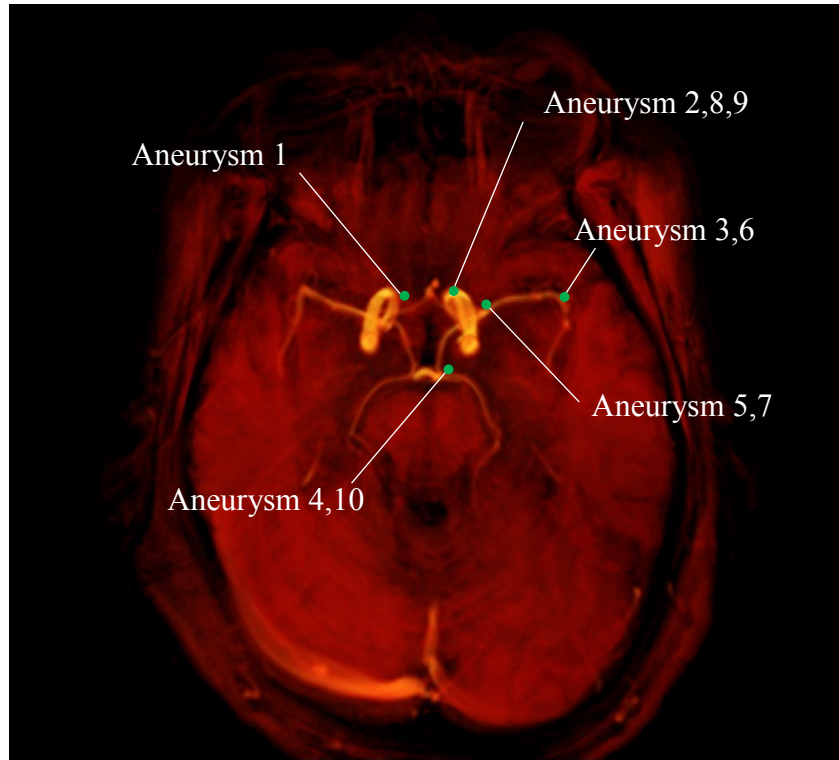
The location of aneurysms 1-10 in the typical cerebral vasculature. Note, the image is generated from Phase contrast-MRI using AMIRA™ 5.4.2 software.
